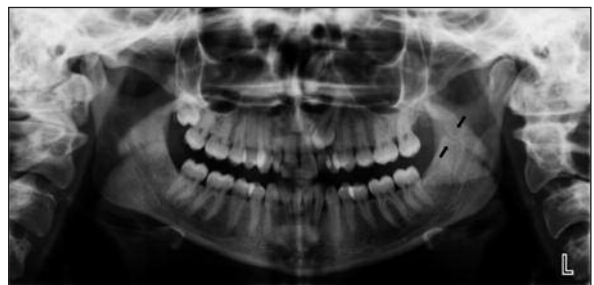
Panoramic radiograph of the patient. Retromolar canal is observed between the black arrows.
